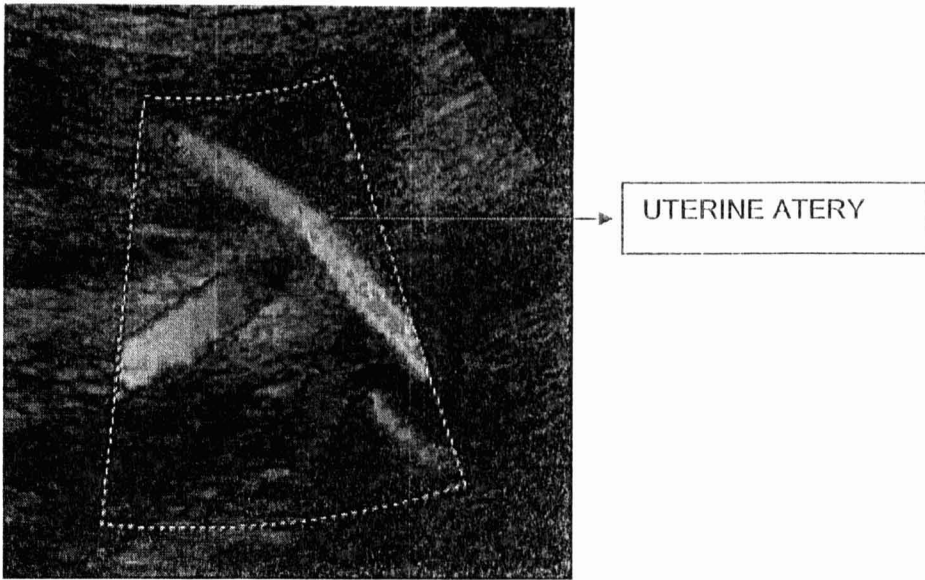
Demonstrating the uterine artery at the apparent crossover with the external iliac artery. (www.fetalmedicine.com/fmf/Doppler%20in%20Obstetrics.pdf)
